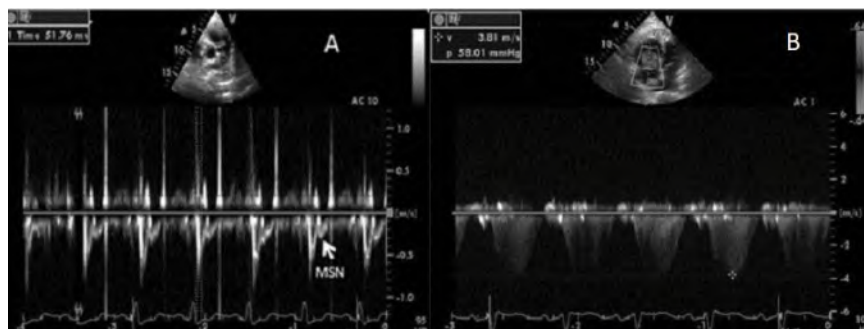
(A) Pulsed Doppler echocardiography in RV outflow truck showing acceleration time of the pulmonary artery less than 60msec and there is the presence of mid-systolic notch (MSN). (B) Continuous Doppler showing peak systolic velocity of the tricuspid regurgitation bigger than 3.8 m/s.
